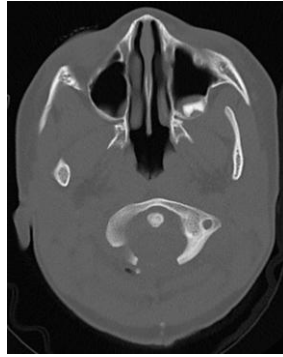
CT of Patient 1 obtained on postoperative day 1 shows resection of the C1 posterior arch. The anterior arch is intact.
